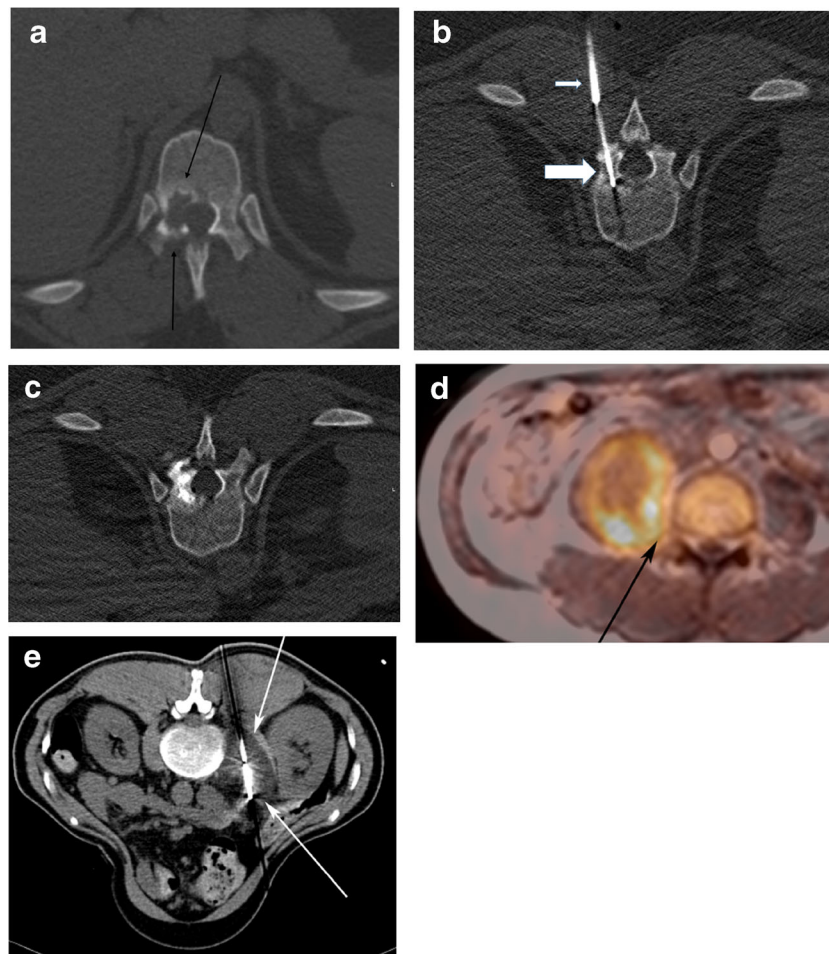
Ablation images demonstrating the range of approaches. a Single axial CT image at the level of T10 in a 47-year-old female with breast cancer and focal back pain demonstrates a 1×2 -cm lytic pedicle lesion (arrows) corresponding to her symptoms. b Through a co-axial anchor (small arrow), a 17 G cryoablation probe [“B” from Fig. 1 (small arrow)] was advanced across the lesion and freeze-thaw cycles undertaken. c The next morning, the patient had polymethylmethacrylate instilled to the ablation bed under combination CT/fluoroscopic guidance. d Single axial PET-MR image in a 61-year-old male with metastatic sarcoma and L4
